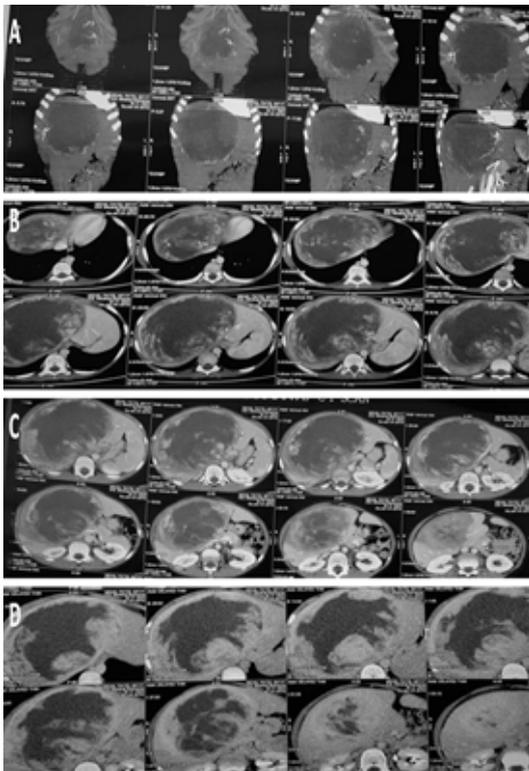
Contrast enhanced computed tomographical examination of abdomen (A) Arterial scan; (B) Portal scan; (C) Venous Scan; (D) Delayed Scan
